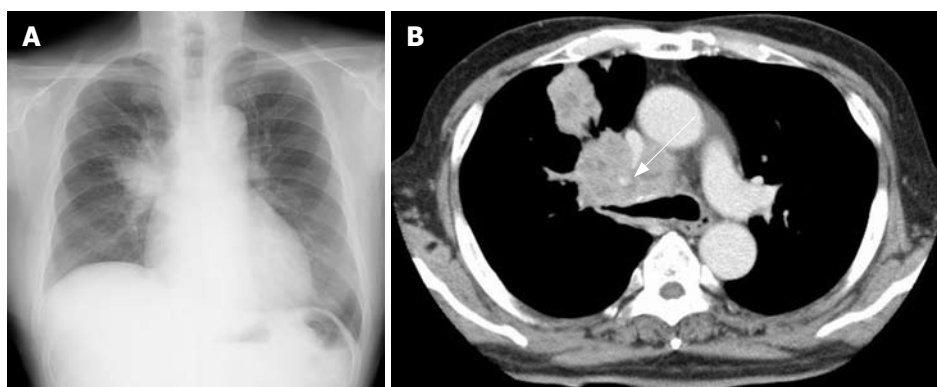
A: Chest X-ray revealed a large abnormal shadow in the right upper lobe; B: A computed tomography (CT) of the chest demonstrated a large lung tumor in the right upper lobe obstructing the right upper bronchus.
